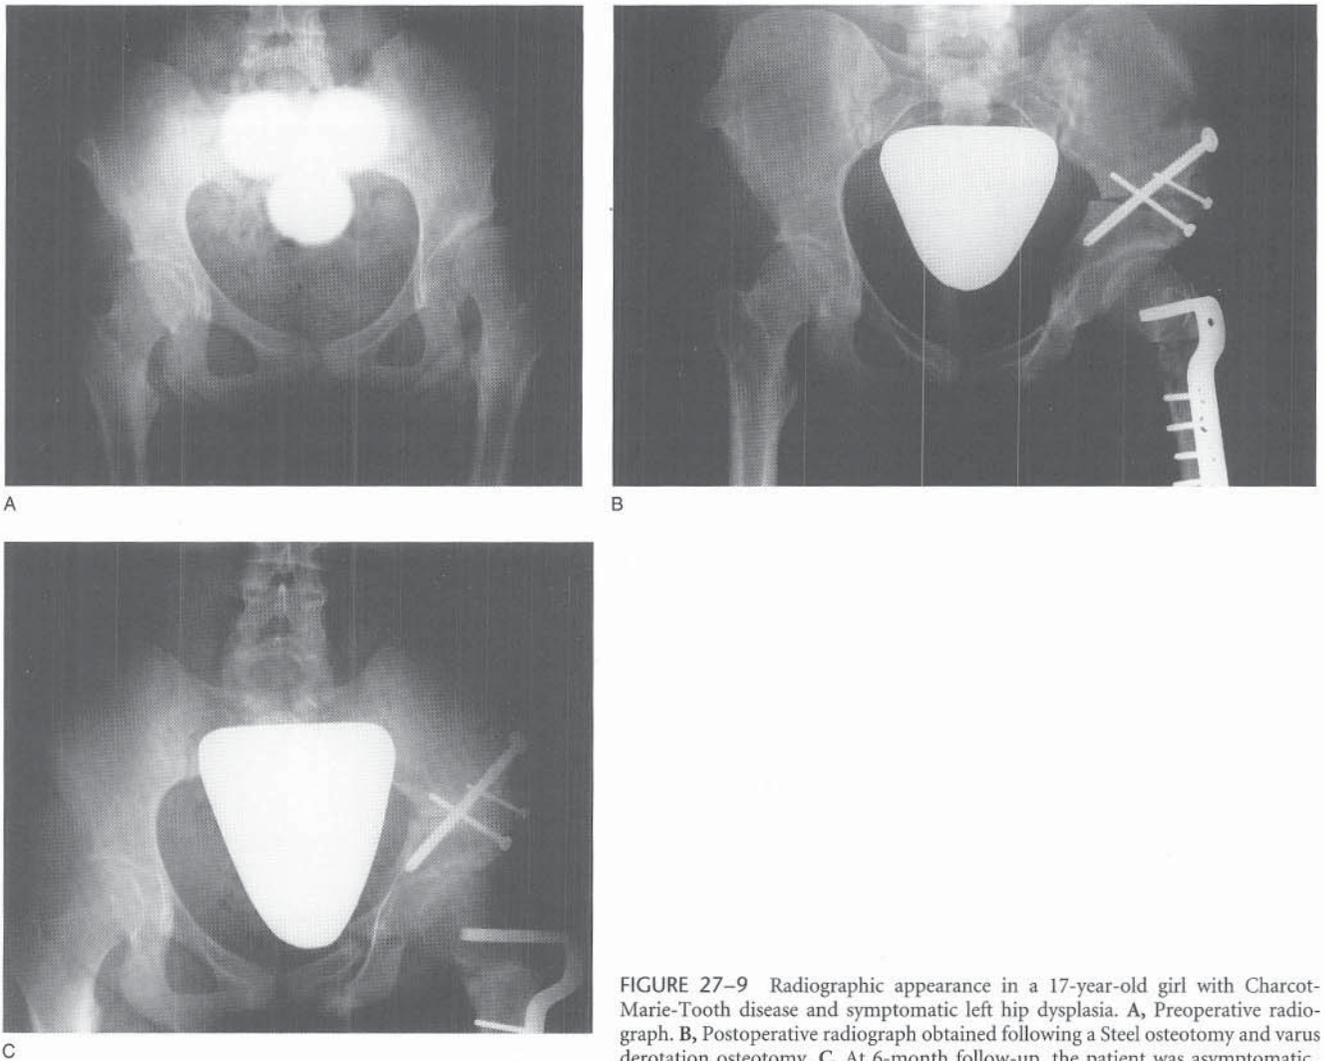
Radiographic appearance in a 17-year-old girl with Charcot-Marie-Tooth disease and symptomatic left hip dysplasia. A, Preoperative radiograph. B, Postoperative radiograph obtained following a Steel osteotomy and varus derotation osteotomy. C, At 6-month follow-up, the patient was asymptomatic.
